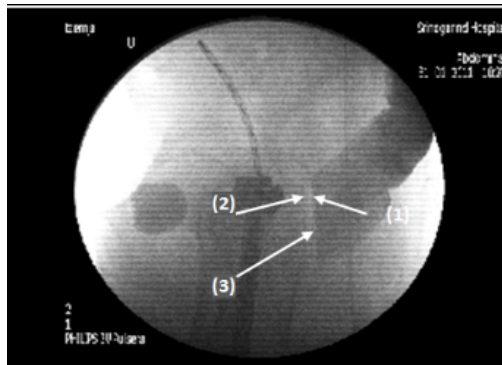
The Contrast-Coated CRT Rectal Radiograph Demonstrated the Location of the Conventional Rectal Tube (1) Which Was Far away from the Anterior Rectal Wall (2)
